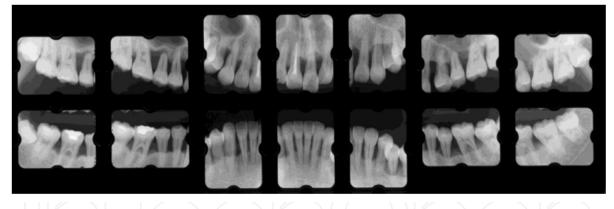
Oral photographs at initial presentation (A) and dental X-rays at initial presentation (B).
